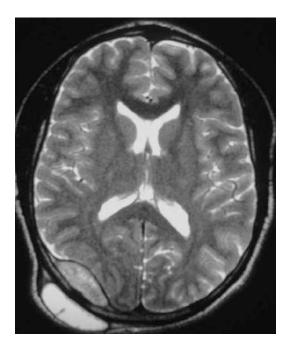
T2-weighted axial MRI section demonstrates an epidural TB abscess in the right occipital region with skull and subcutaneous involvement (From O'Brien et al. [18] with permission)
